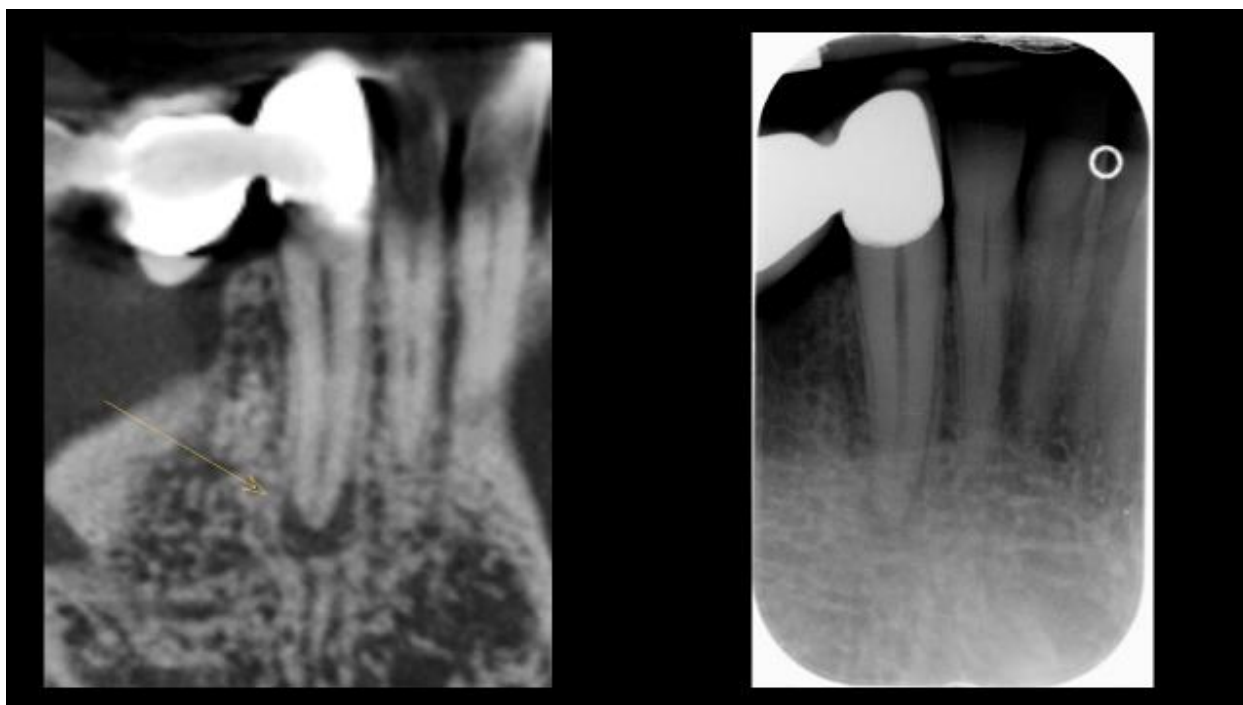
Apical lesion #27 CBCT (right) visible on PA (right)
